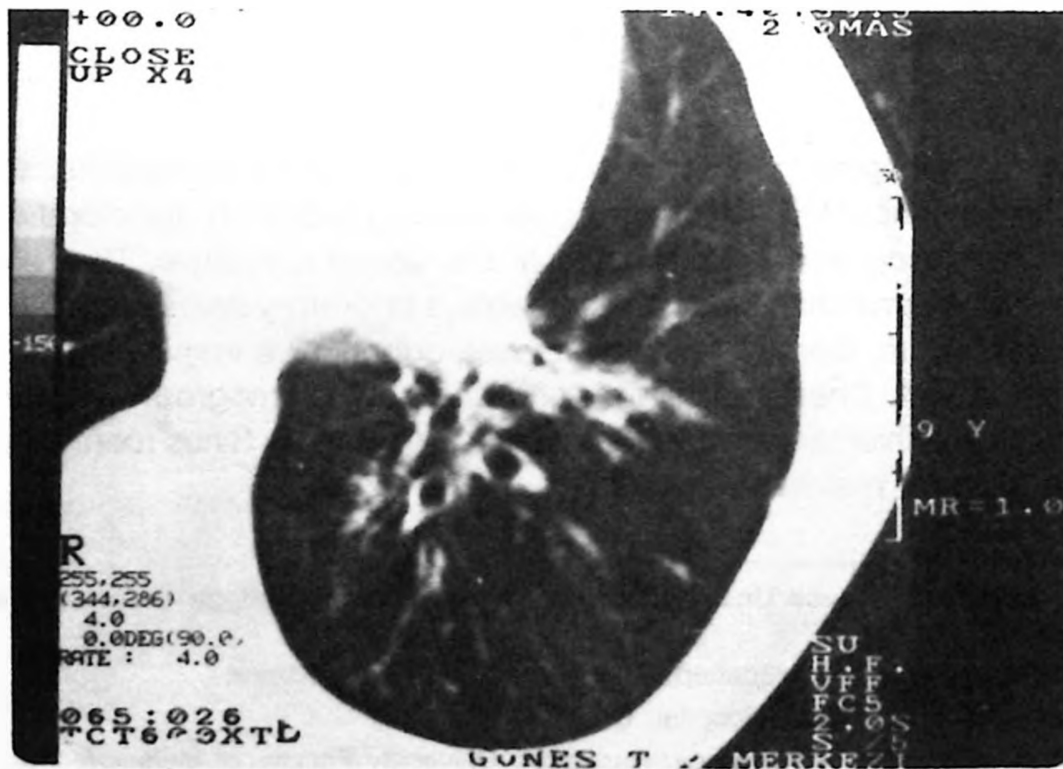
Computed tomography of the thorax showing bronchiectasis in the lower left lobe.
